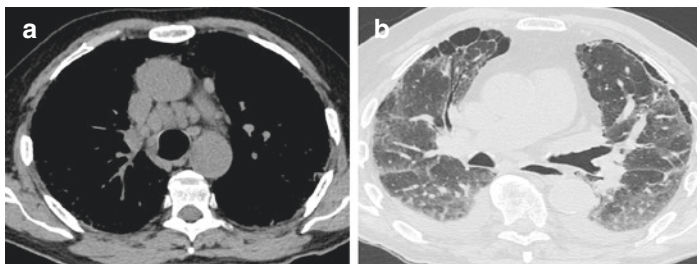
(a) HRCT mediastinal window shows multiple mediastinal lymphadenopathies. (b) Parenchymal window: bilateral reticular subpleural opacities and bilateral pleural effusion in a preexisting chronic obstructive pulmonary disease in a 73-year-old man
